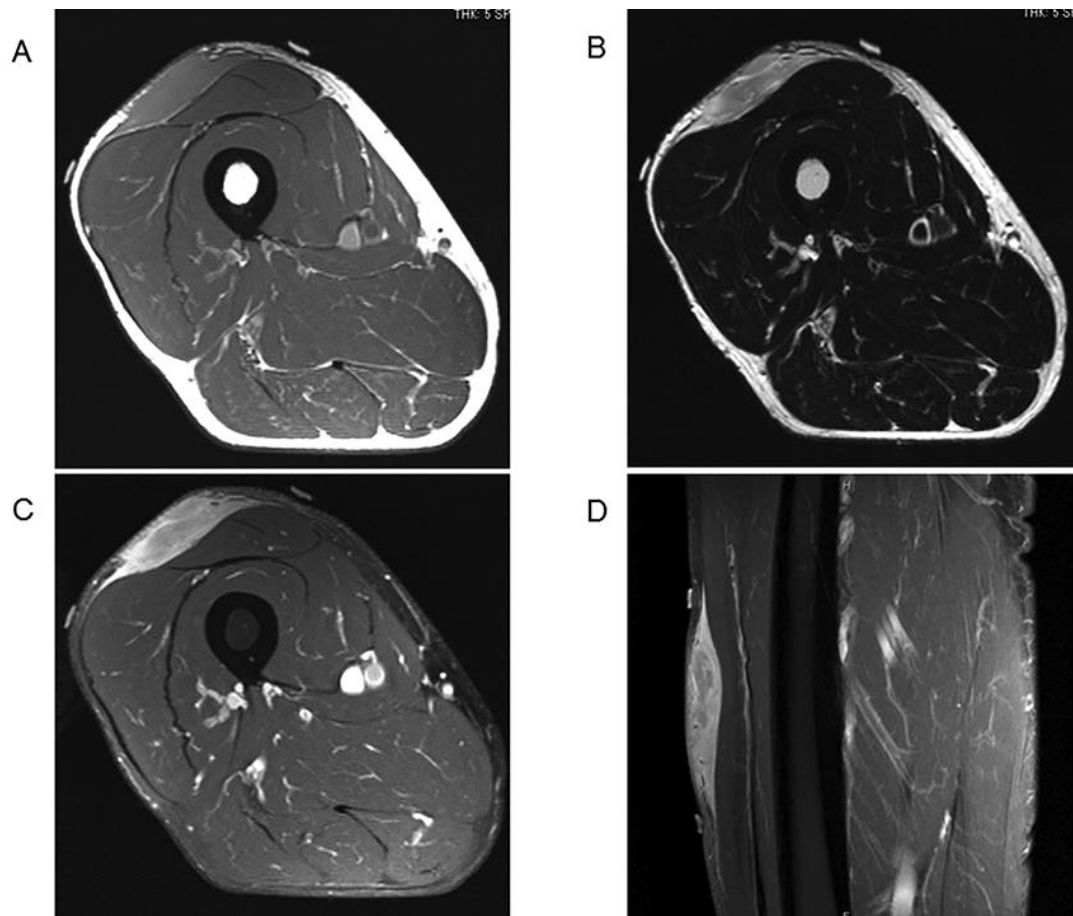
On MRI, the tumor is 8.6 × 13.3 cm in size and resides in the anterior thigh. The lesion is low intensity on T1WI (A) and high intensity on T2WI (B). Gadolinium-contrast administration showed enhancement of the lesion (C, D).
